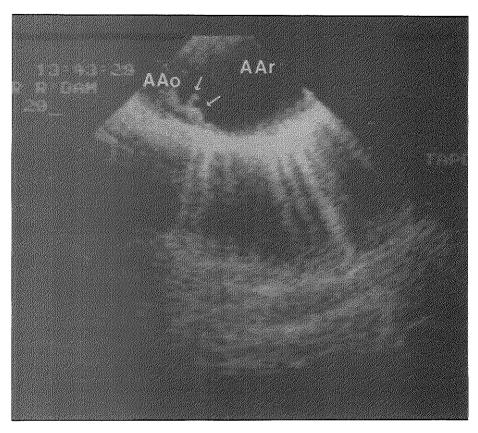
Transesophageal echocardiogram. Aortic wall irregularities (arrows) typical of atherosclerotic plaques. AAo, ascending aorta; AAr. aortic arch.
